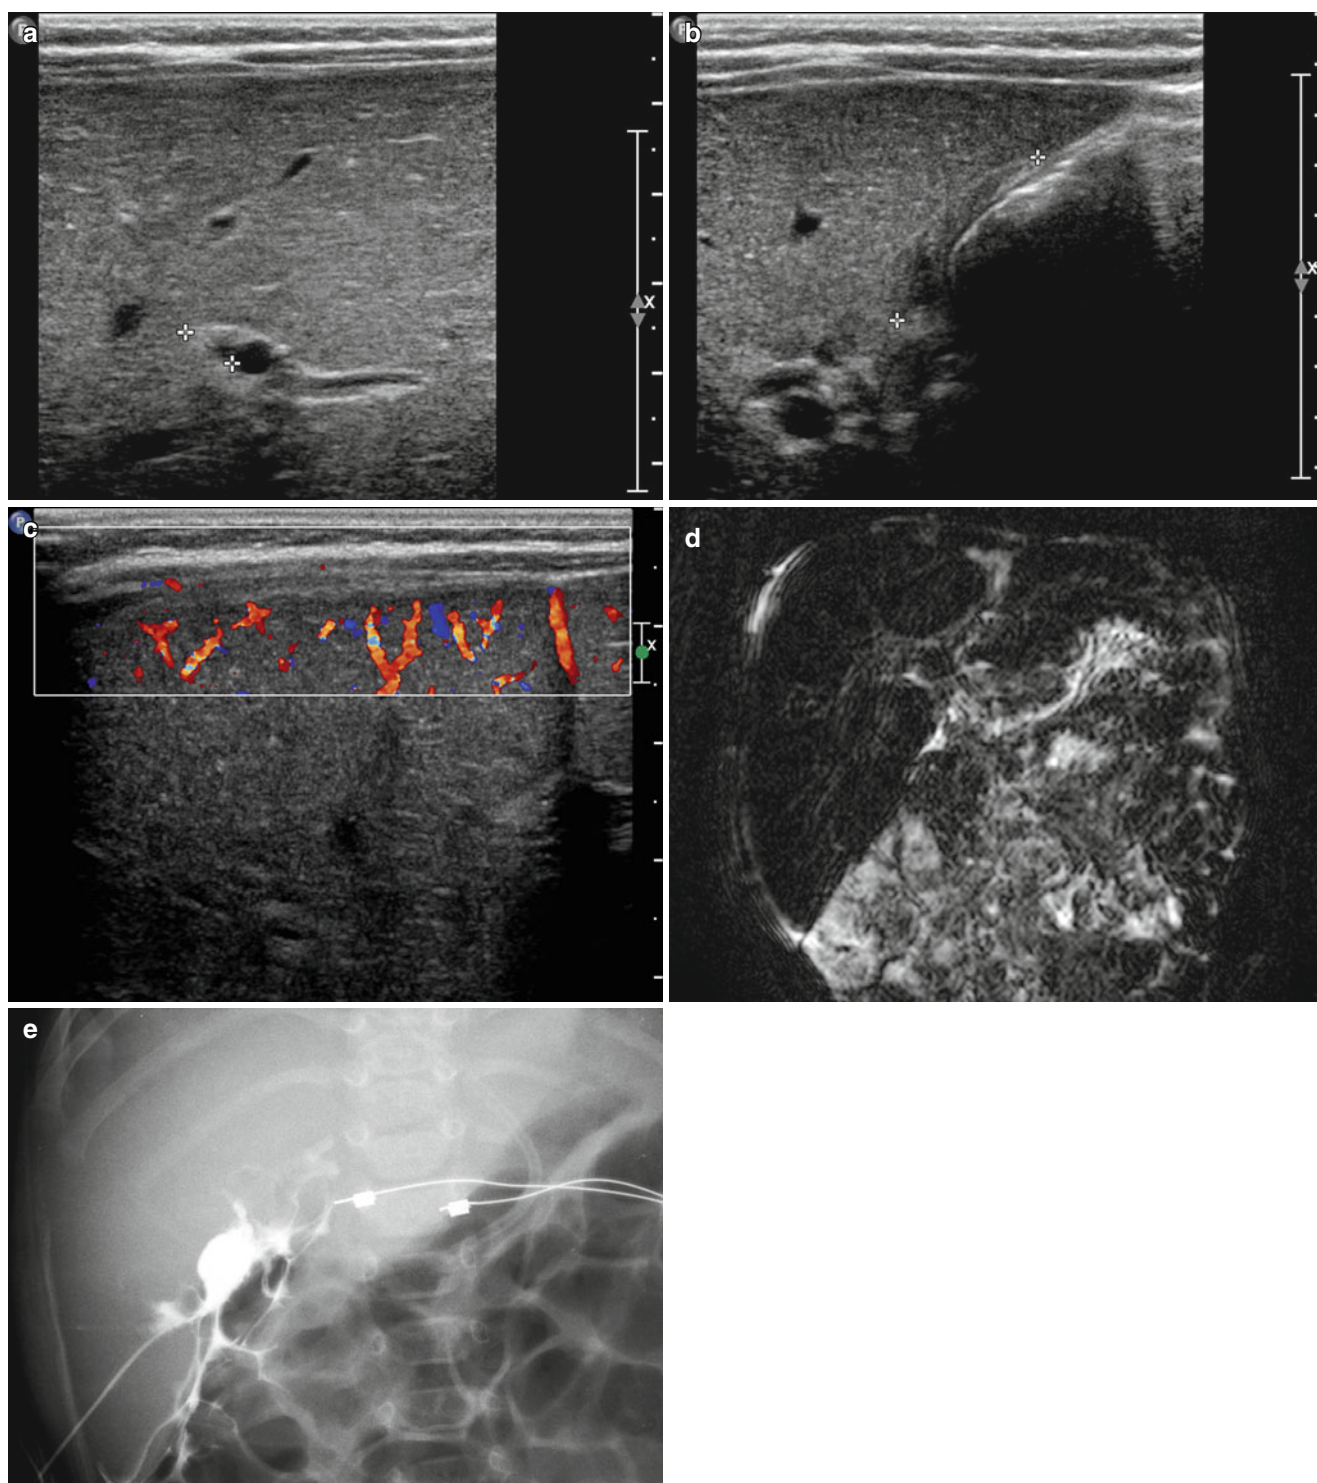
Biliary atresia in a 3-month-old boy. (a–c) Abdominal US images show increased periportal echogenicity in liver (a), atretic gallbladder (b), and increased hepatic subcapsular flow on Doppler US (c).
